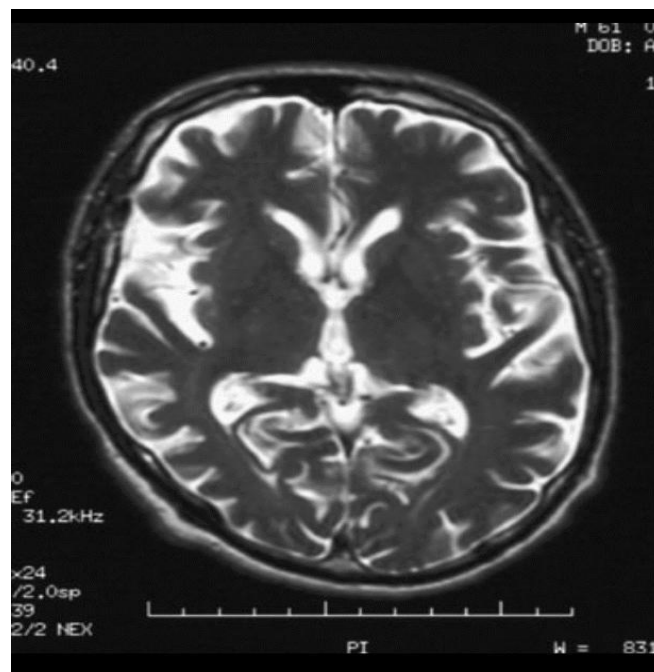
Axial, T2-weighted magnetic resonance imaging (MRI) scan shows dilated sylvian fissure resulting from adjacent cortical atrophy, especially on the right side.
